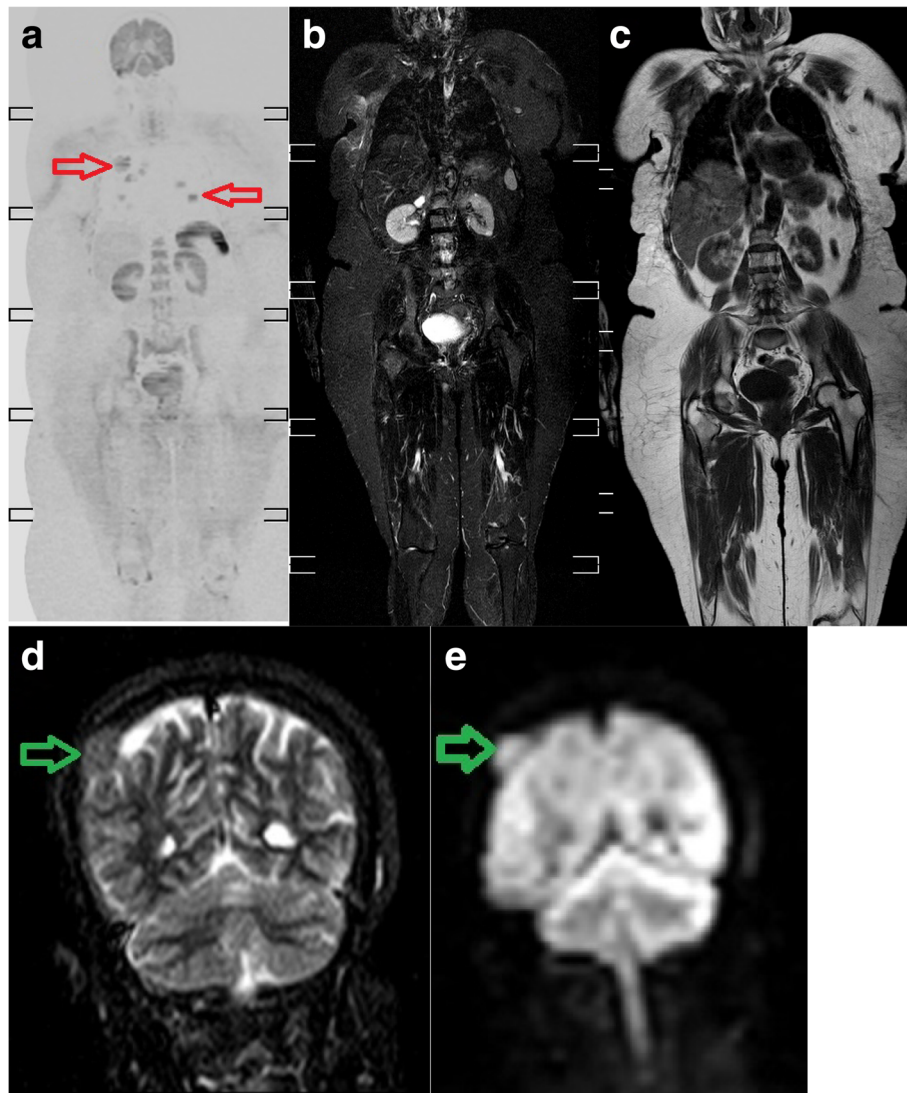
A 61-year-old female patient, diagnosed with right breast cancer. Metastatic lesions were suspected. a Inverted grey scale coronal WB-DWI: multiple cannon ball metastatic lesions (red arrows) distributed bilaterally which are not seen in coronal STIR (b) or coronal T1 WI (c). Right parietal bone metastatic lesion (green arrows) seen as hyper intensity in coronal STIR (d) and restricted diffusion in coronal DWI (e)
